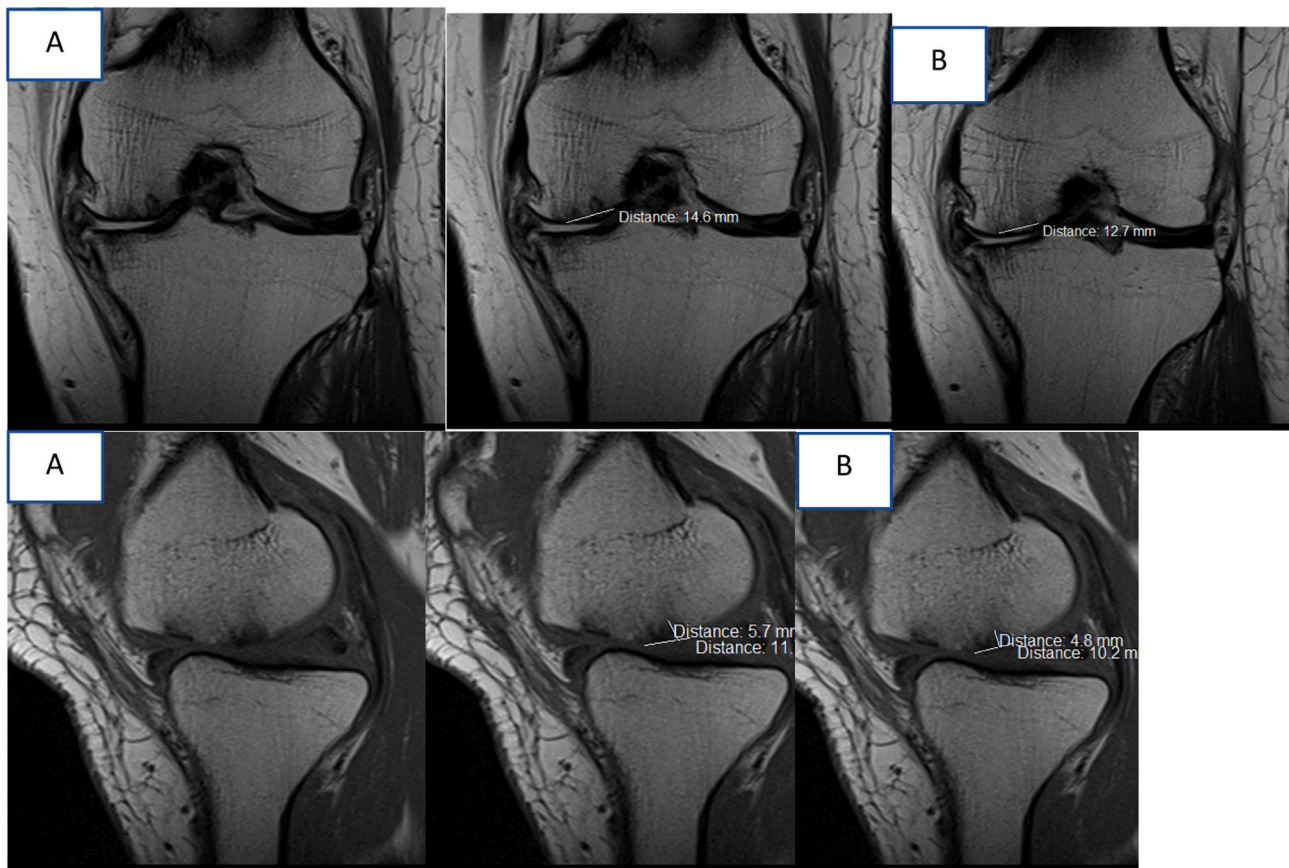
Patient 1 A. MRI pre-operative and 6 month post-operative showed improvement of cartilage (preoperative 14,6 mm, postoperative 12,7 mm), AMADEUS score 40 (grade 3) and postoperative AMADEUS score 50 (grade 3).
